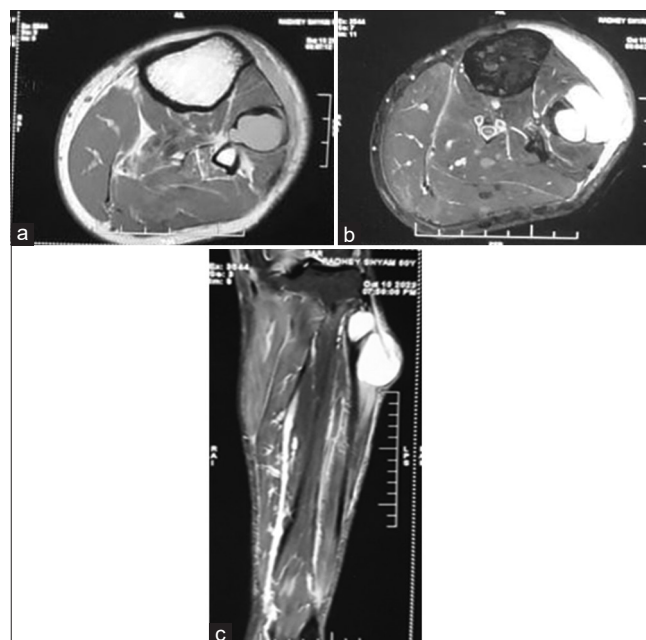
Magnetic resonance imaging shows a multiloculated fluid-filled cystic lesion, which is iso- to hypointense on T1W1 (a) and hyperintense on T2/STIRW-weighted image (b and c) with its epicenter within the extensor digitorum longus muscle in the upper part of leg and abutting the proximal fibula posteriorly. It is also extending anterolaterally and slight inferiorly, tracking into the overlying subcutaneous fat plane
